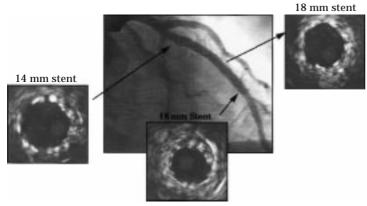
(a) Multiple cross-sections at different levels along the mid-segment of the left anterior descending coronary artery: note the discrepancy between the short lesion shown with angiography and the diffusely diseased segment observed with ICUS. (b) The intracoronary ultrasound findings allow a complete coverage of the stenotic segment with an optimal angiographic result after high-pressure dilatation, confirmed with ultrasound. CSA = cross-sectional area.
